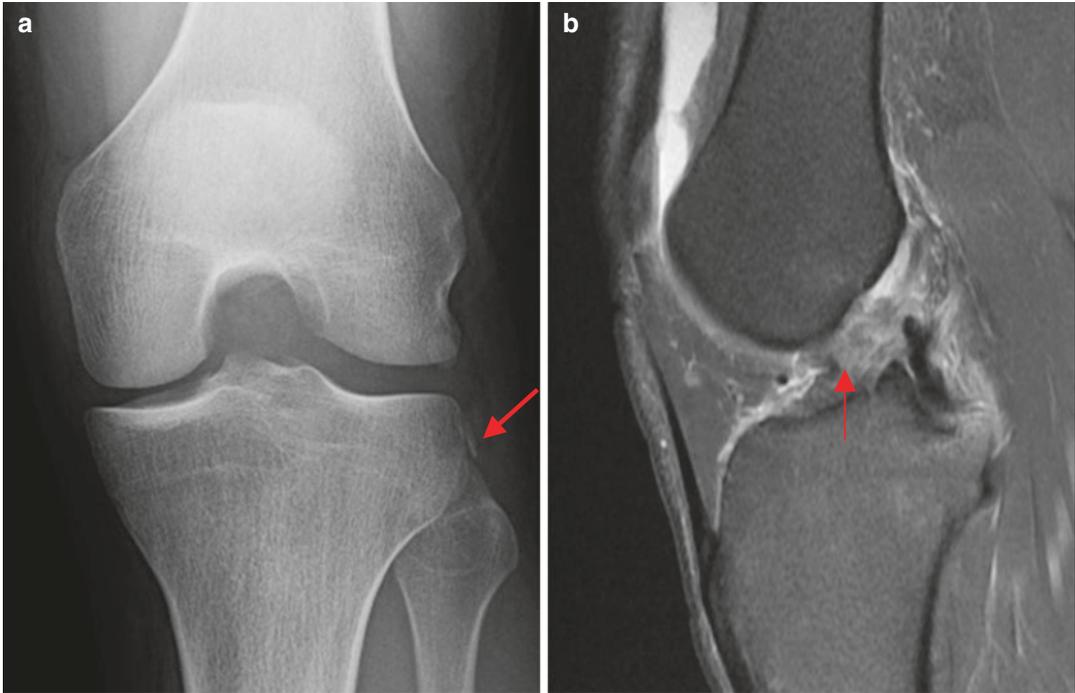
(a) AP X-ray of patient with acutely ruptured ACL. Second fracture indicated by red arrow. (b) MRI demonstrating acute ACL rupture
